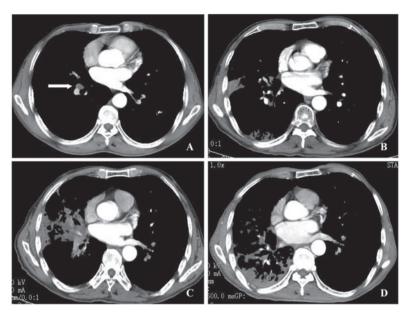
Thoracic computed tomography scan of an 83-year-old man with adenocarcinoma of the right lung. (A) Prior to radiotherapy; (B) 6 months after radiotherapy (mild obstructive pneumonia); (C) 9 months after radiotherapy and 2 weeks after gefitinib initiation (severe obstructive pneumonia in the middle lobe of the right lung); (D) 14 months after radiotherapy (obstructive pneumonia in the middle lobe of the right lung is relieved and obstructive pneumonia in the inferior lobe of the right lung is aggravated). White arrow, location of tumor.
